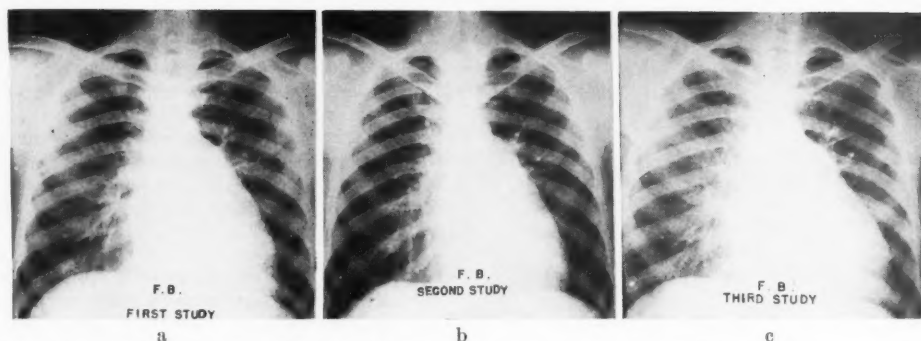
Serial roentgenograms in patient 699 (F. B.). The posteroanterior 6-foot films were taken (a) at the time of the first, (b) the second and (c) the third cardiac catheterization. For discussion see text.
